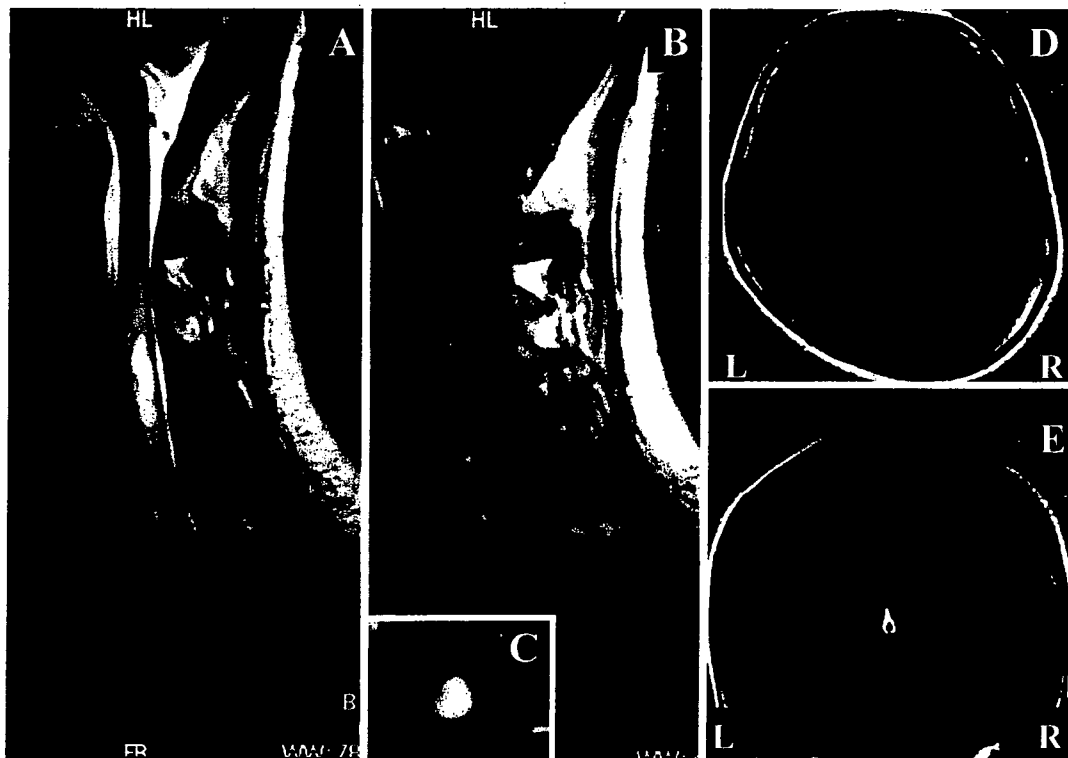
Cervical cord MRI showed a long extending swollen lesion with a strong contrast enhancement in C3-C7 during acute transverse myelitis (A, B). The contrast-enhanced lesion occupied the central gray matter and extending to the posterior column of the cervical cord (C). Brain MRI showed a few high signal lesions in the cerebral deep white matter, juxtacortical white matter and bilateral internal capsules extending to the upper pons on T2 images (D, E).
